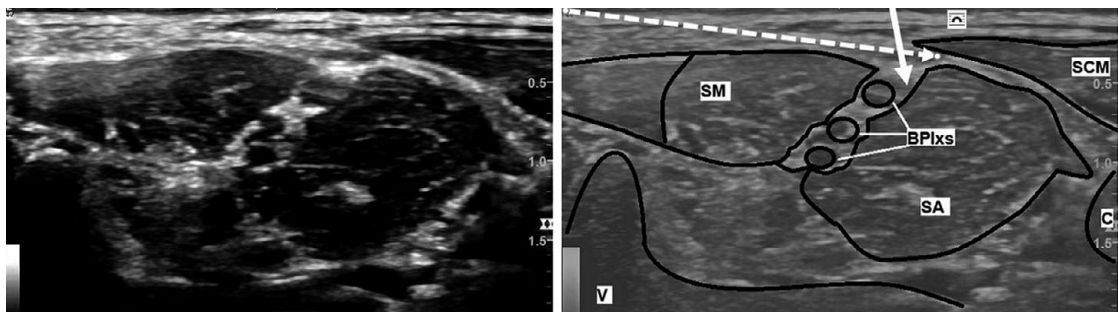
Ultrasound appearance of the brachial plexus in the interscalene region (BPlxs); scalenus medius (SM), scalenus anterior (SA), sternocleidomastoid (SCM), vertebra (V) and carotid artery (C).
